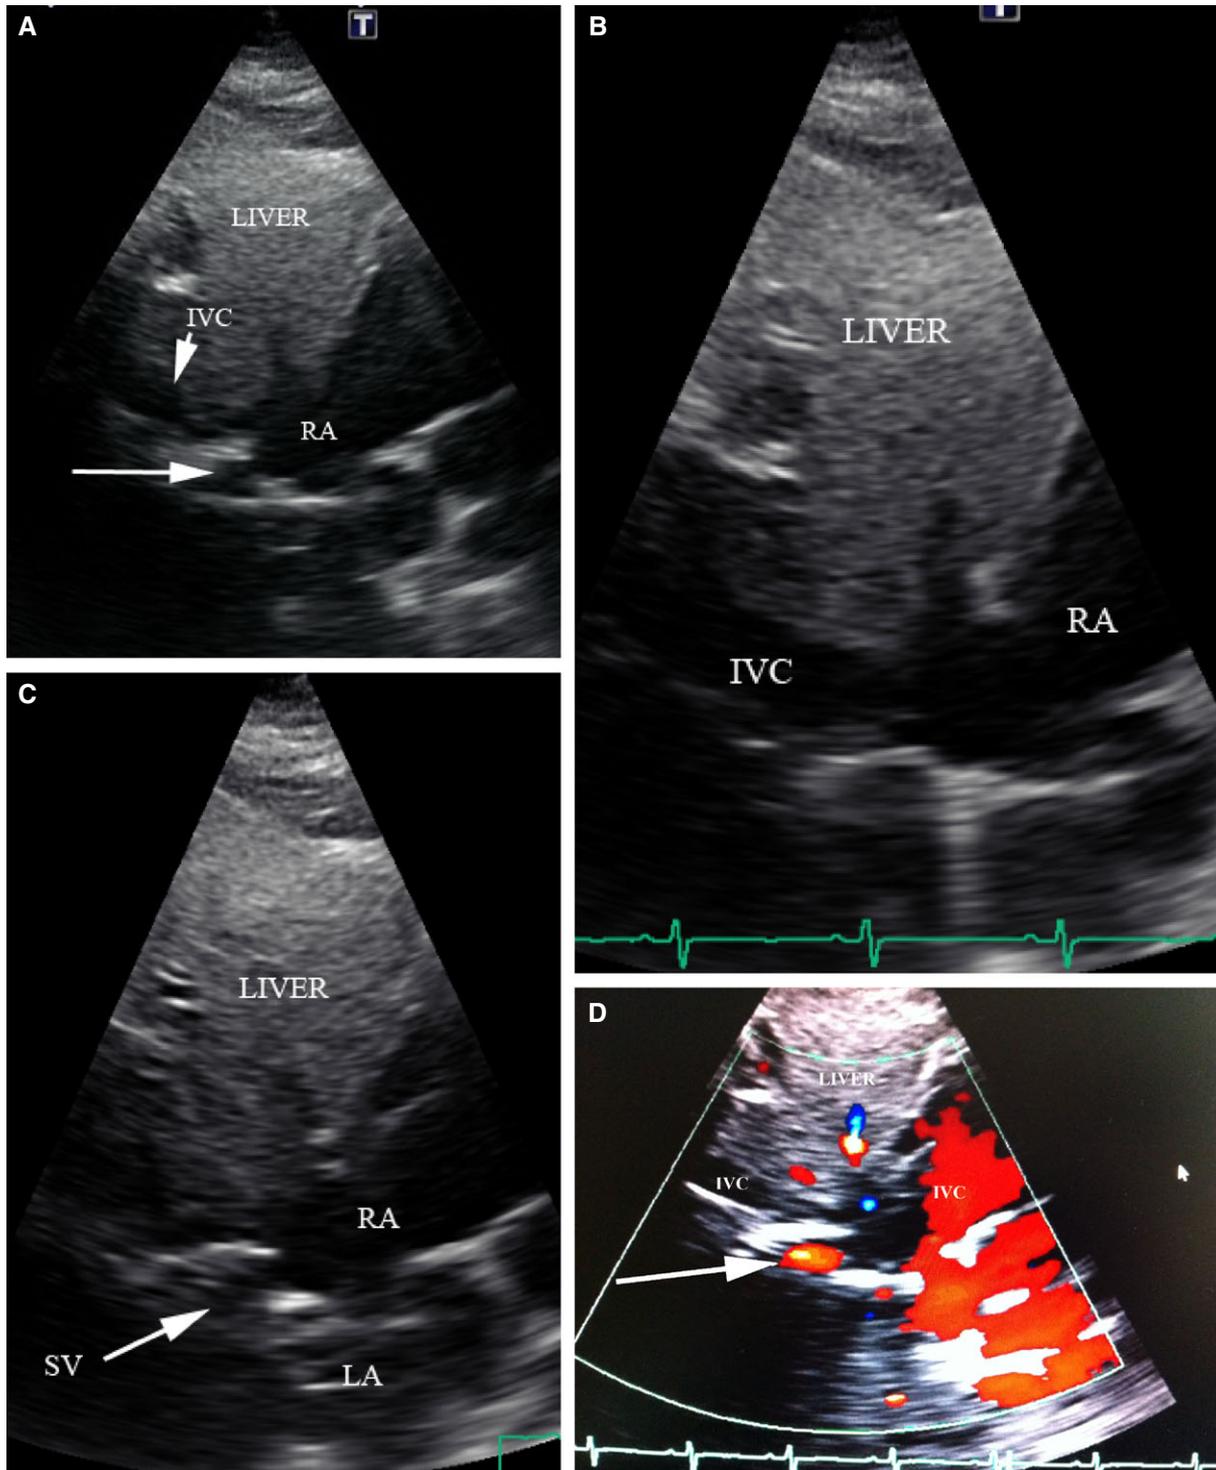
Subcostal imaging demonstrates the SV draining into the IVC just above the diaphragm. A. Visualization of the IVC, SV (horizontal arrow) and IVC-RA junction. B. Best visualization of the IVC, but loss of the SV. C. While imaging the IVC in its long axis, movement of the transducer slightly clockwise and toward the right shoulder, allowed the SV to be visualized. D. Color Doppler demonstrates laminar flow within the SV (red jet).
